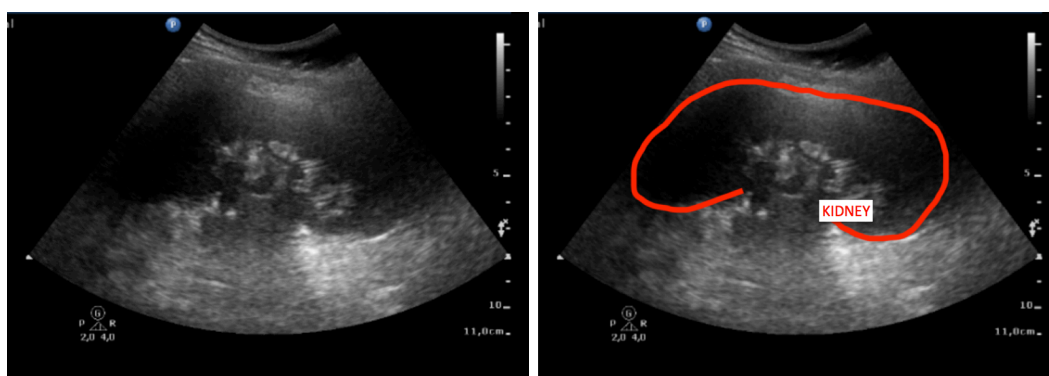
Ultrasonographic image of the left kidney.
